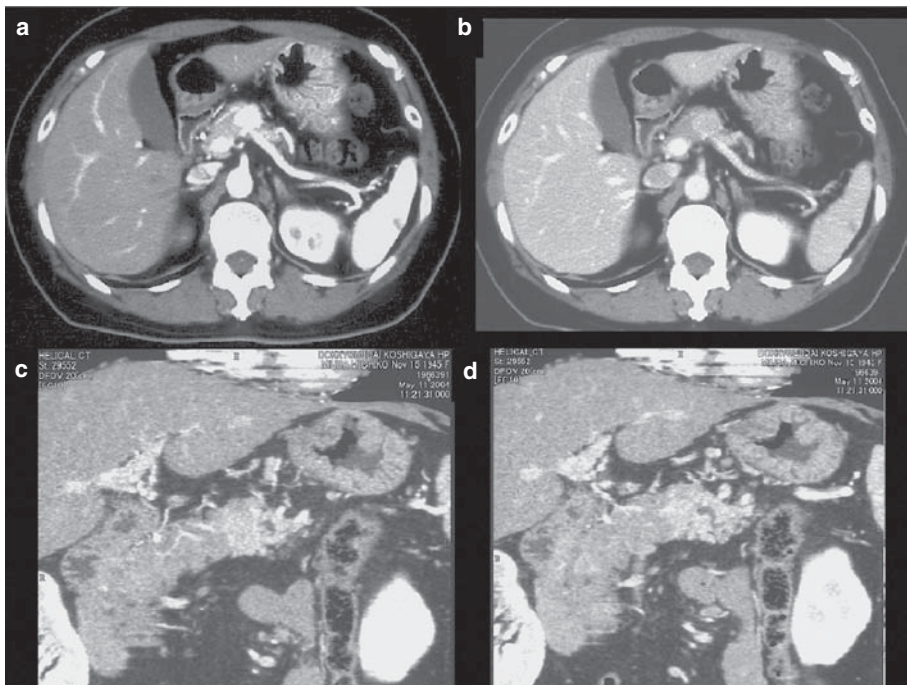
Computed tomographic images of the pancreas showing a well-enhanced solid tumor in the body (a early phase, b late phase) and the dilated distal pancreatic duct (c, d)
